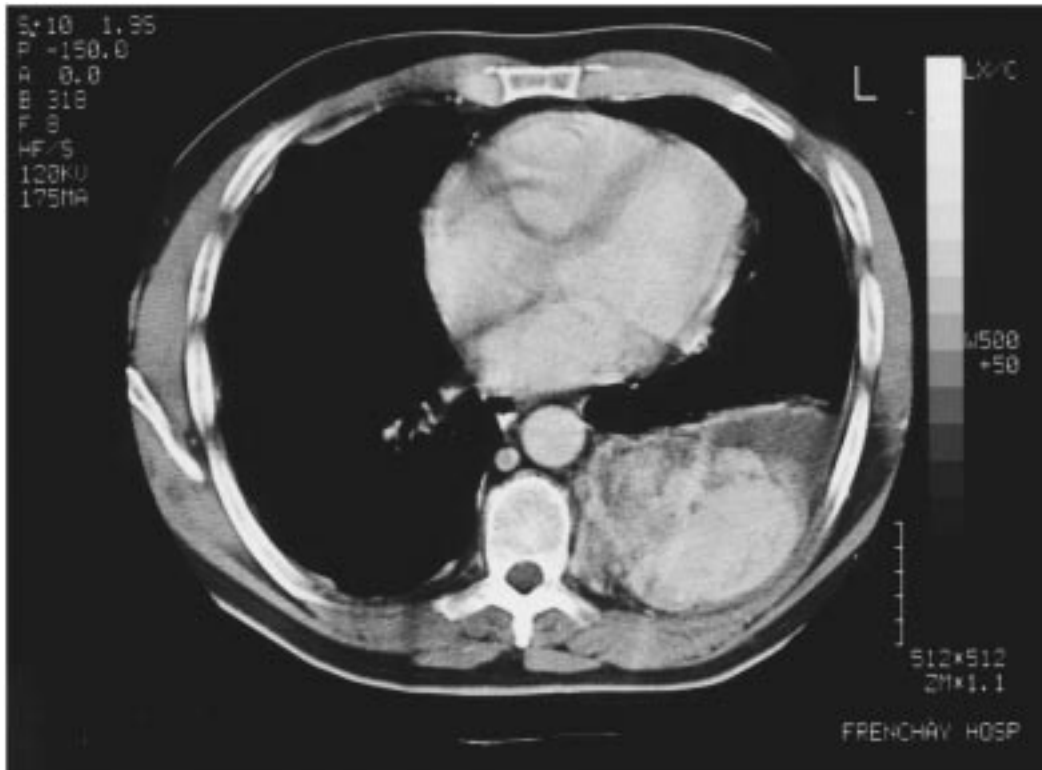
Pre-radiotherapy contrast CT scan showing highly vascular chest wall haemangiopericytoma.
